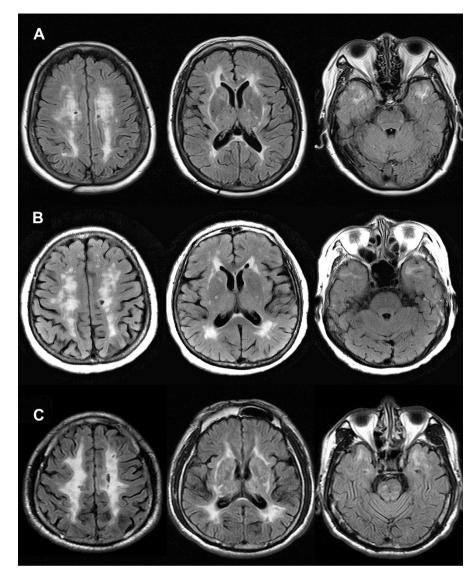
Fluid attenuated inversion recovery (FLAIR) images depicting multiple lacunar infarcts and diffuse leukoencephalopathy with involvement of corona radiata, external capsules, and anterior temporal poles in III-4 with a homozygous *NOTCH3* p.R544C mutation (A), her sister (III-1) with a heterozygous *NOTCH3* mutation (B), and another unrelated 61-year-old female with a heterozygous *NOTCH3* p.R544C mutation (C).
